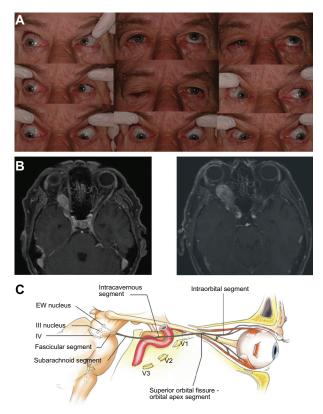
(A) Ocular motility in the nine cardinal positions of gaze. There is a complete right upper-eyelid ptosis (center panel, center row). In addition, there is limited elevation of the right eye (upper row). The clinical findings are consistent with a right superior divisional CN III palsy. (Patient consent obtained to present clinical images). (B) Axial, contrast-enhanced, TI-weighted magnetic resonance images with fat suppression show a right orbital apex enhancing mass one month after symptom onset (left, measuring 1.6 cm × 1.0 cm) and 2 months later (right, measuring 3.1 cm × 1.7 cm). (C) Sagittal view of CN III.
